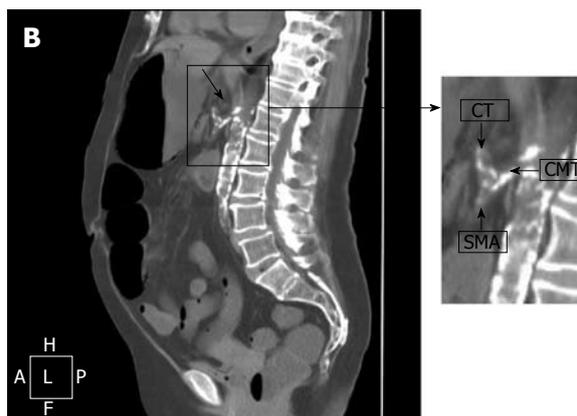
Computed tomography of the abdomen. A: Pneumatosis of the wall of stomach and small bowel (arrow in the right). Intraparenchymal air in ventral portions of the left liver and fourth segment (arrow in the left); air within the branches of the mesenteric vein (arrow in the centre); B: Thrombosis of the celiacomesenteric trunk (CMT) (arrow). In the detail: common origin of celiac trunk (CT) and superior mesenteric artery (SMA) from the CMT.
